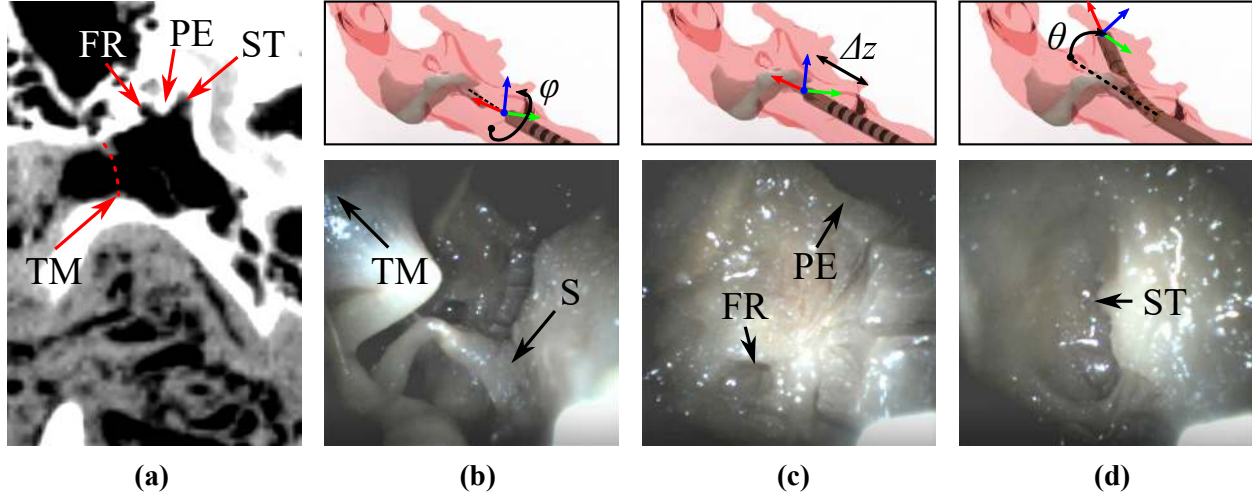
Visualization of the sinus tympani as enabled by the steerable tip: (a) CT scan of the middle ear space with callouts to relevant structures, (b) actuation in ϕ rolls the scope to align the field-of-view (where top shows a rendering of the scope in the middle ear, and bottom shows the endoscope image), (c) actuation in z inserts the endoscope further into the ME, past the tympanic membrane and ossicular chain towards the pyramidal eminence, and (d) deflection of the tip in θ allows for visualization of the sinus tympani.
